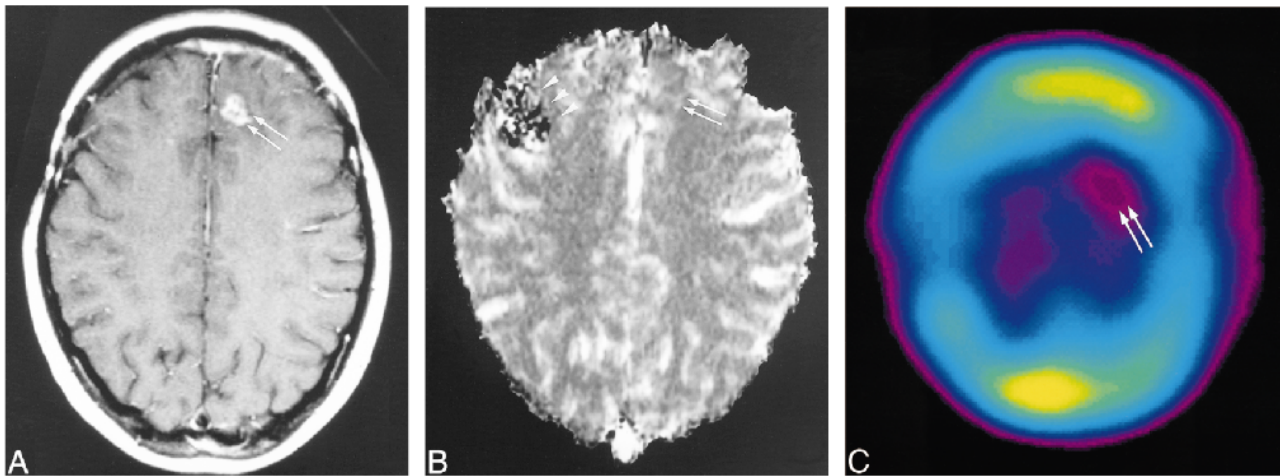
20-year-old woman without tumor recurrence. The diagnosis was based on the disappearance of the enhancing area on serial MR images.
